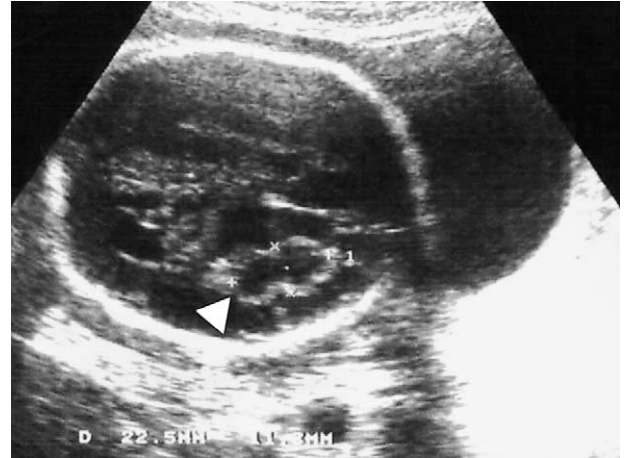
Cranial ultrasonography 4 weeks after the initial hemorrhage (axial section through the cerebral hemispheres): the previous image has evolved into a cystic cavity in the left frontoparietal area (arrowhead).
